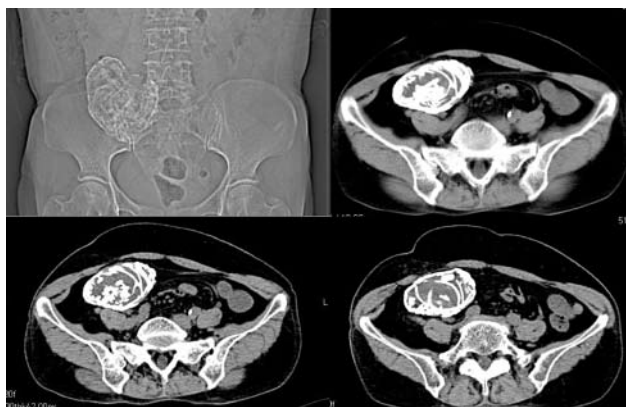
Abdominal X-ray and computerized tomography showing a low-level echogenic mass in the right pelvic cavity.
